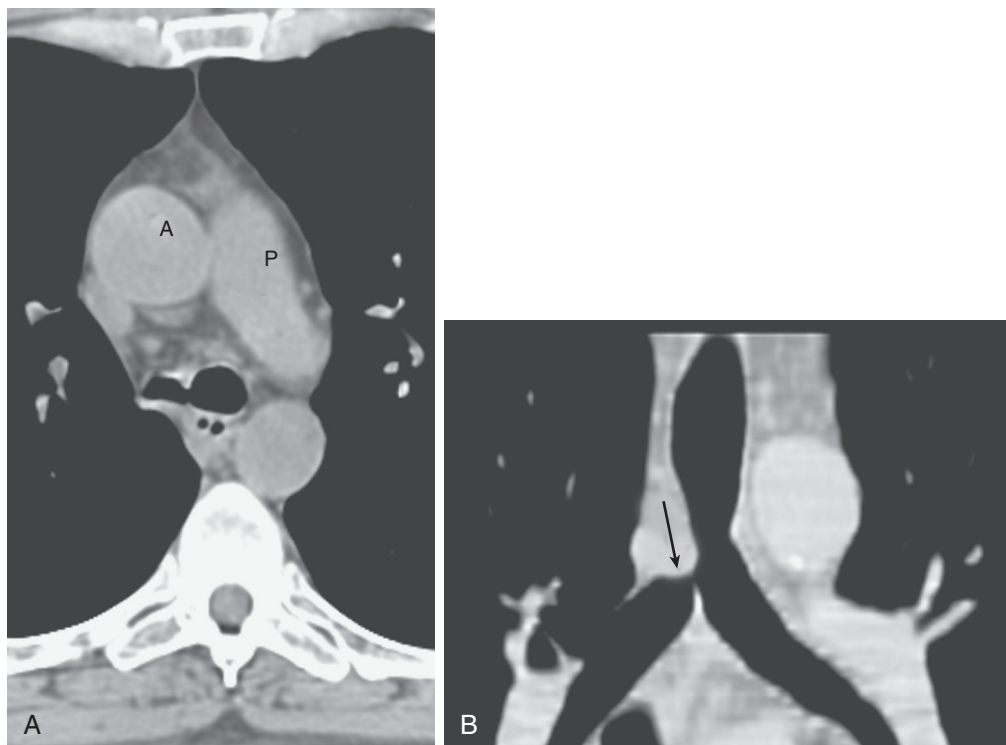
■ Focal stenosis of the right main-stem bronchus from invasive aspergillosis. A, Axial computed tomography shows normal caliber of left main bronchus and marked concentric narrowing of right main bronchus. B, Coronal reconstruction shows that the right main bronchus stenosis involves a short focal segment (arrow). A, Ascending aorta; P, pulmonary artery.
